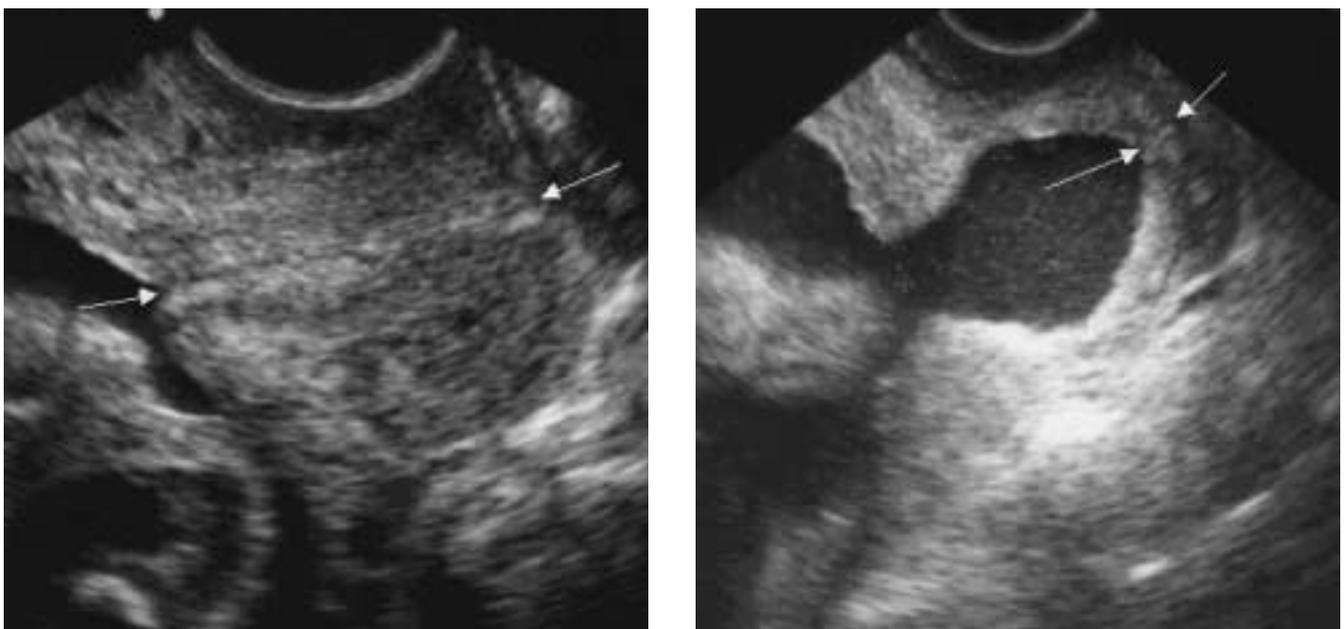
Measurement of cervical length by transvaginal sonography. On the left is a normal cervix and on the right there is severe shortening with marked funneling
